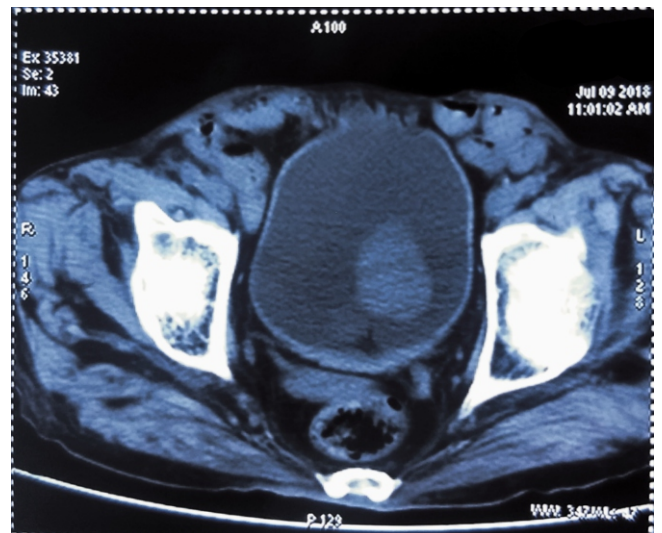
CT abdomen and pelvis showed an 8 cm size, confined oval growth arising postero-inferiorly to bladder
